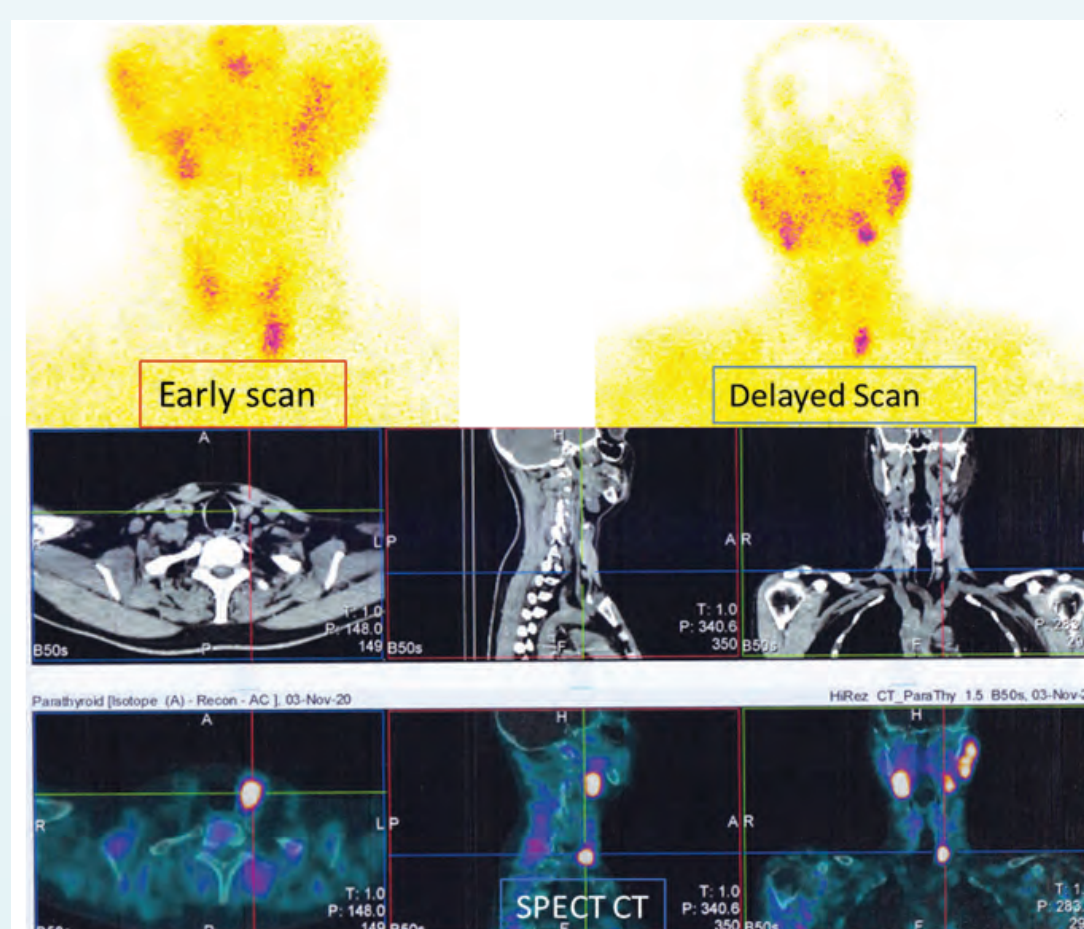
^{99m}Tc-MIBI Parathyroid scan - early, delayed planar & delayed SPECT CT showing positive uptake for left lower parathyroid adenoma.
